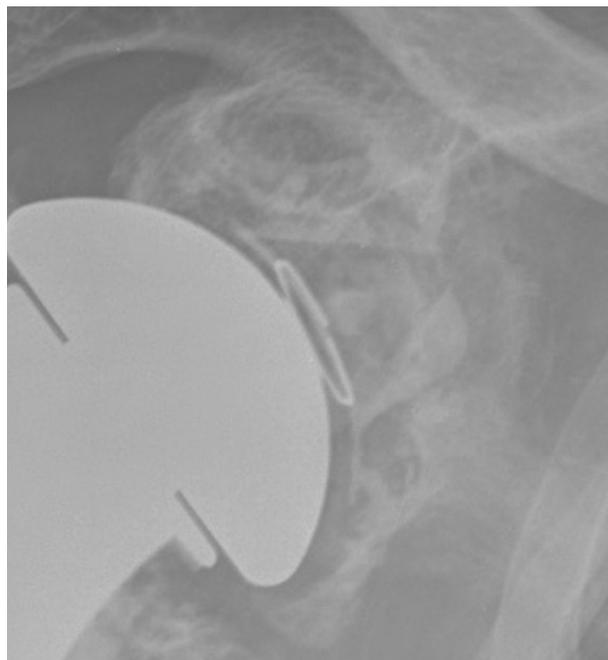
Radiographic loosening of a keeled glenoid component with medial migration and gross radiolucency.
